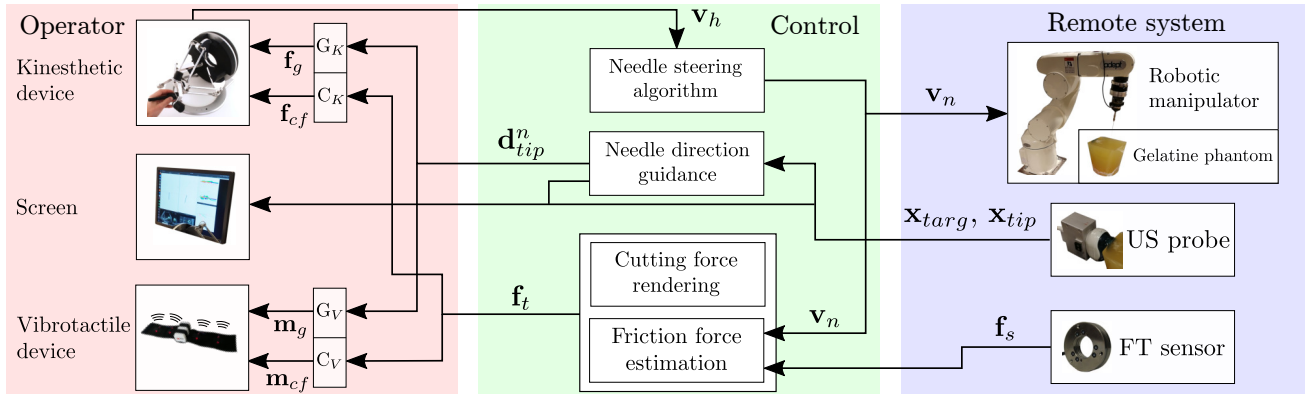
Haptic teleoperation system. The operator uses a grounded kinesthetic device and a wearable vibrotactile armband (left). A needle steering algorithm (center) translates the human operator’s velocity commands  $v_h$  into a velocity  $v_n$  for the 6-DoF Viper robot (Omron, JP), which houses a 6-axis force/torque (FT) sensor (ATI, USA) and the needle (right). During the insertion, a friction force estimation algorithm filters the FT sensed forces  $f_s$  and estimates those due to the penetration of the needle tip into the tissue,  $f_t$ . A 3D ultrasound (US) probe enables the tracking of the needle  $x_{tip}$  and target  $x_{target}$  at runtime, while a steering algorithm calculates the best needle tip direction to reach the target objective,  $d_{tip}^n$ . The user receives navigation guidance (G) and needle cutting force (C) using a combination of kinesthetic (subscript K, forces  $f_g$  and  $f_{cf}$ ) and vibrotactile (subscript V, vibrating motors frequencies  $m_g$  and  $m_{cf}$ ) feedback. On the screen, the operator sees the ultrasound images and a real-time reconstruction of the needle pose.
